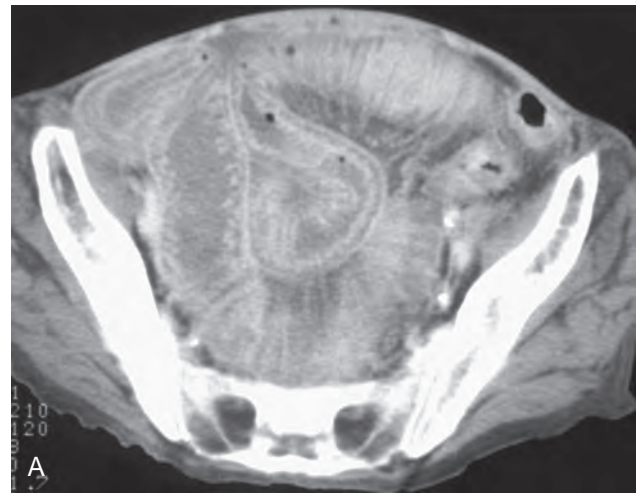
SMV thrombosis. A. Axial contrast-enhanced CT demonstrates severe thickening of the small bowel and right colon as a result of venous occlusive ischemia. The intense mucosal enhancement with submucosal hypodensity and edema represents an example of the target or halo appearance. B. Axial contrast-enhanced image demonstrates thrombus (arrow) within the SMV, representing the cause of the patient's bowel ischemia.
